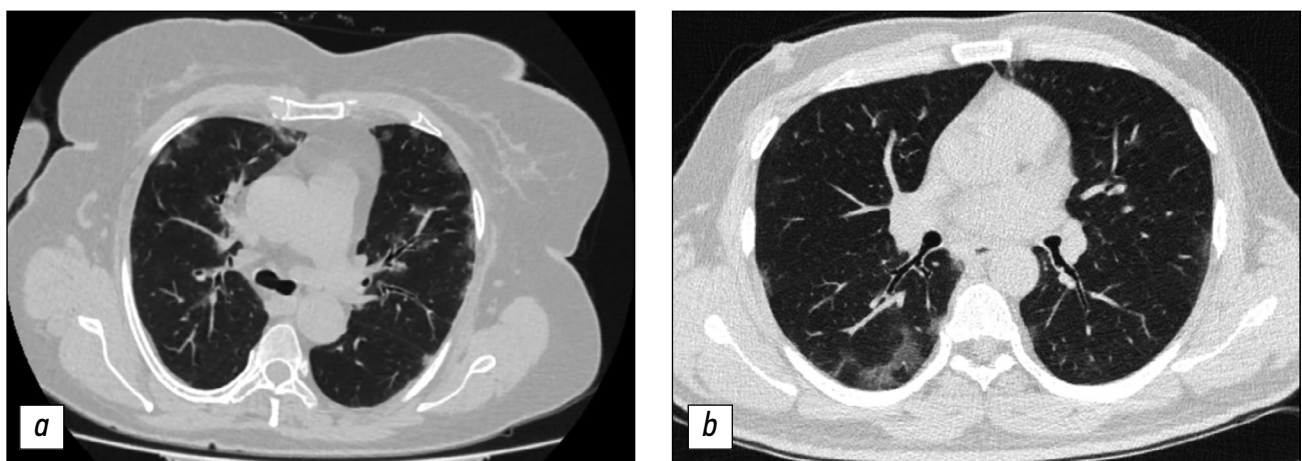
Computed tomography of the chest organs; comparison of viral pneumonia images before and during the COVID-19 pandemic: *a* — multiple subpleural sites of ground-glass opacity of the lung tissue (April 2019); *b* — a similar presentation of an atypical pneumonia of viral origin (April 2020).
